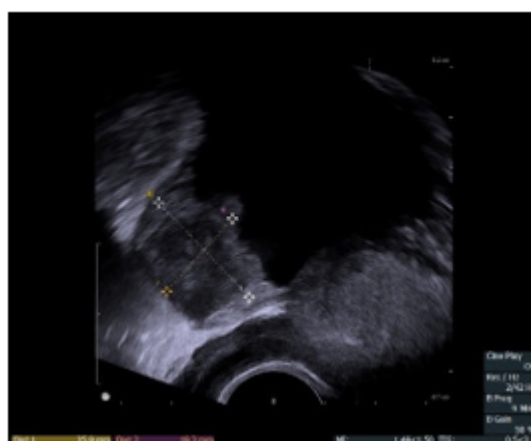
Bladder ultrasound, delineation of the tumor.
